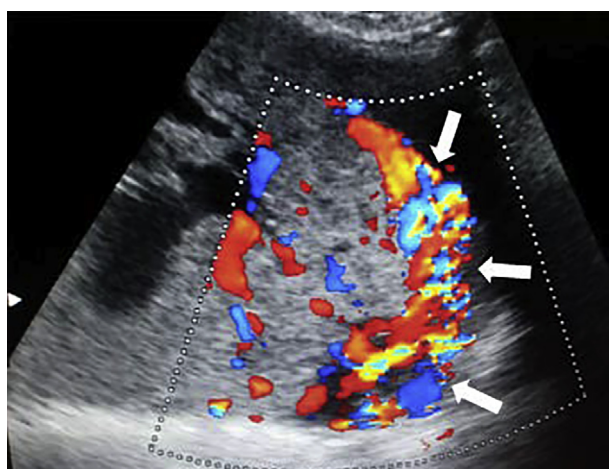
(A) Gray scale transvaginal: Arrow shows placental lacunae. (B) Color Doppler of the same region shows turbulent flow of venous, arterial or mixed blood. (C) Color Doppler of the same region shows Tornado sign (arrow).
